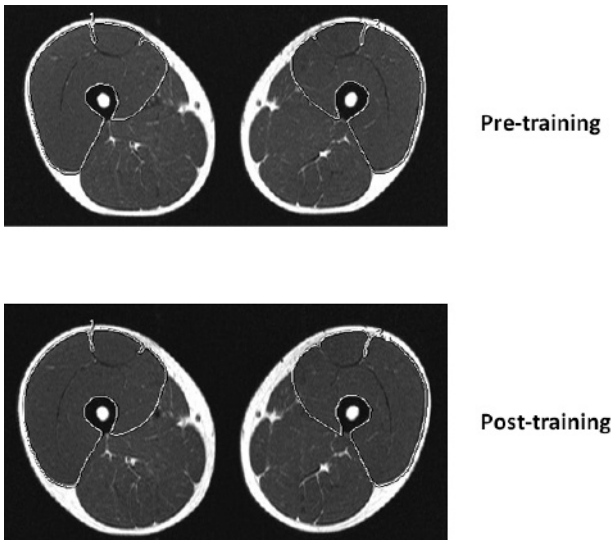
Magnetic resonance image of the quadriceps femoris before and after a period of strength training
